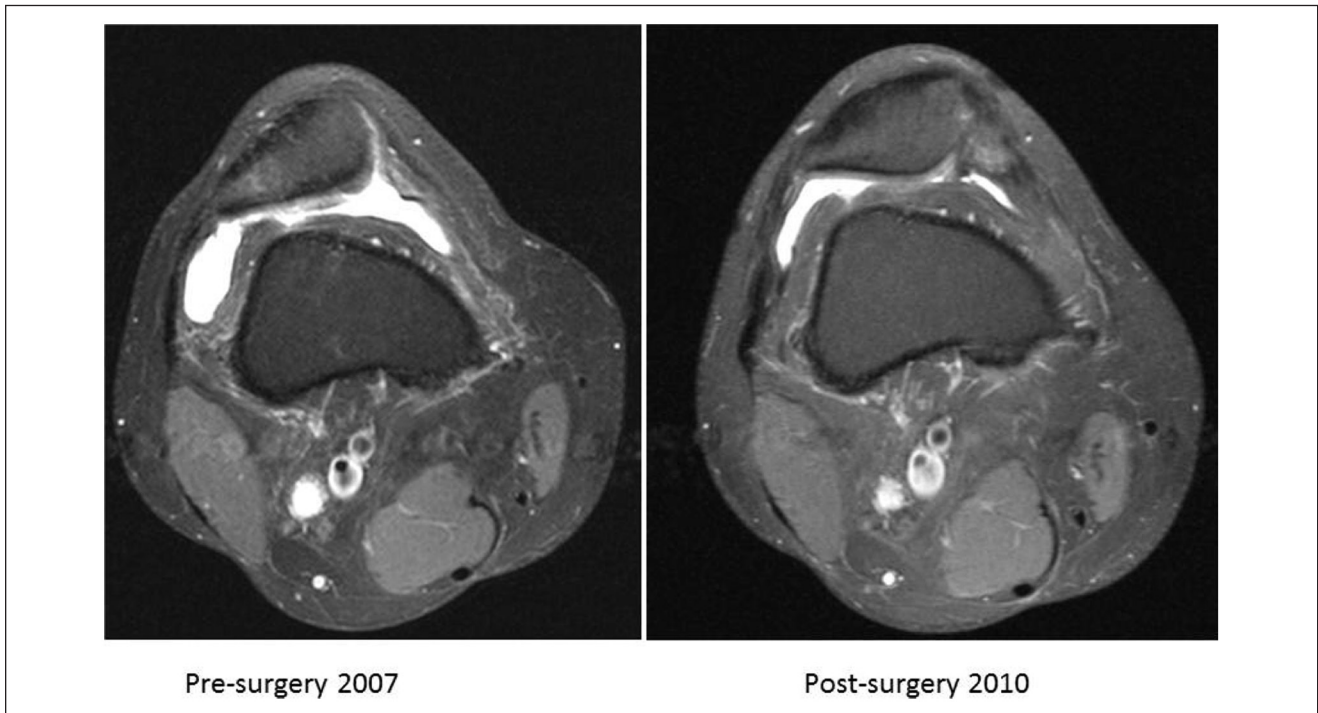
MRI scans before the lateral release procedure and MRI image of the control 1 year postoperatively. Transversal view.
